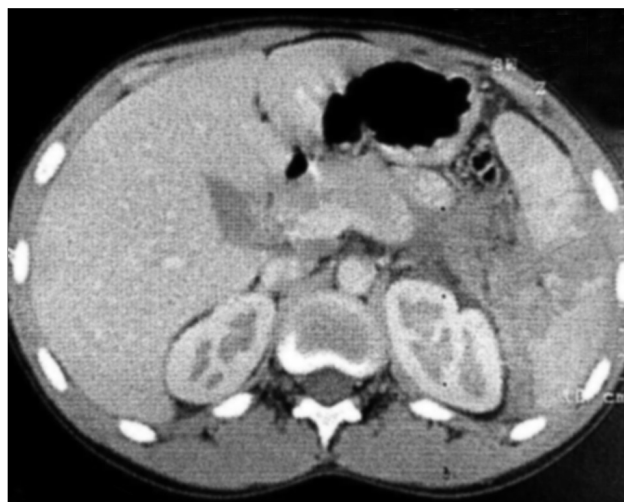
CT shows grade IV splenic injury
